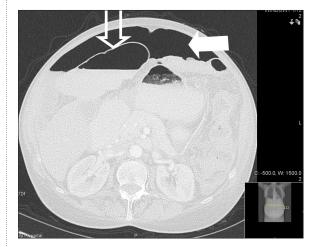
CT Abdomen showing dilated intestine (open arrow) and pneumoperitoneum (closed arrow).
